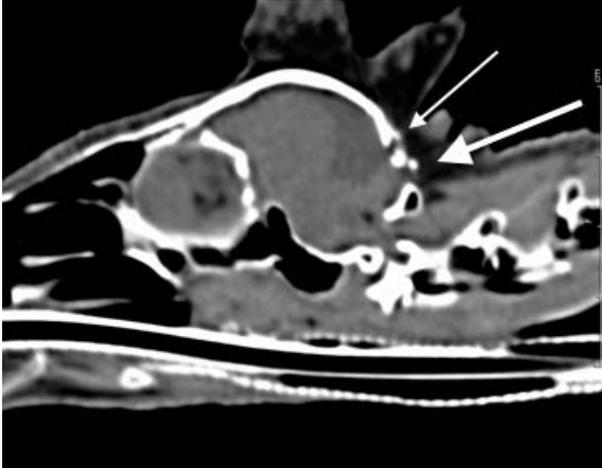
Computed tomographic image of the skull of a juvenile male crested pekin duck that exhibited ataxia, erratic head movements, and microphthalmia. Note the malformation of bone (white arrows) in the caudal aspect of the cranium.
